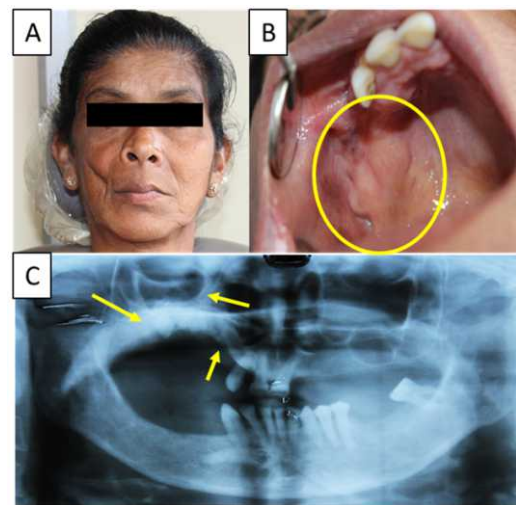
Clinical images (A & B); Orthopantomograph showing course trabeculation, small sinus and impacted 13 (C).
